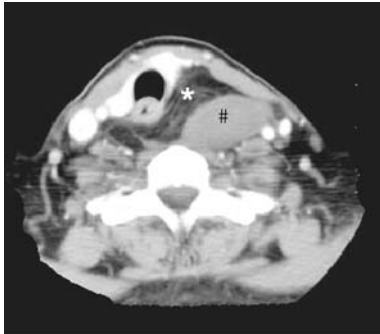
3. CT scan of patient with large retropharyngeal mass (*) with fatty attenuation. There are prominent septations within the fatty attenuation areas compared to the mass seen in figure 1. In addition, a solid component is also seen posterolaterally (#). These features are suggestive of a liposarcoma.
